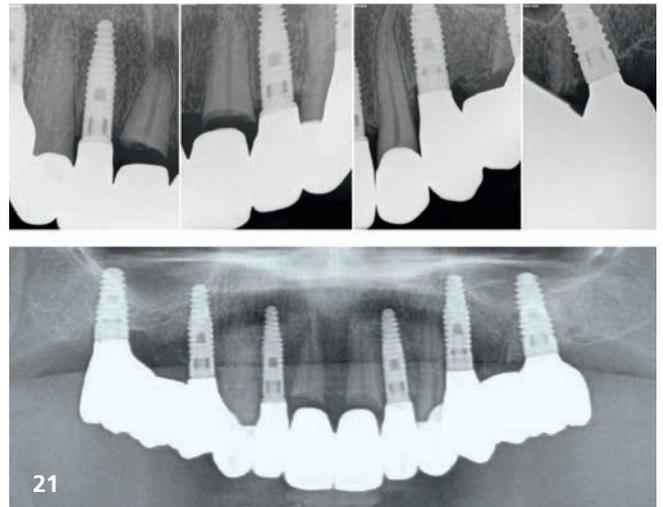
Radiographic control after the two-year follow-up period, showing no visible bone loss at the implant sites and no signs of periapical inflammation at submerged roots.
